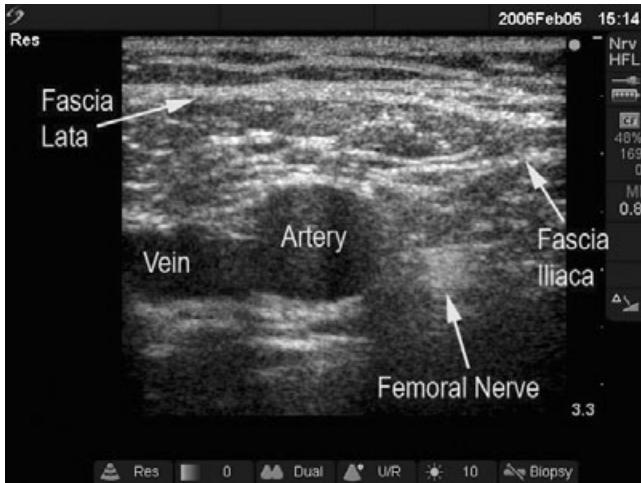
Ultrasound view of the femoral nerve, artery, and vein just caudal to the inguinal ligament. Note the nerve is deep to the fascia that laterally becomes two distinct fascial planes, the fascia iliaca and fascia lata.
